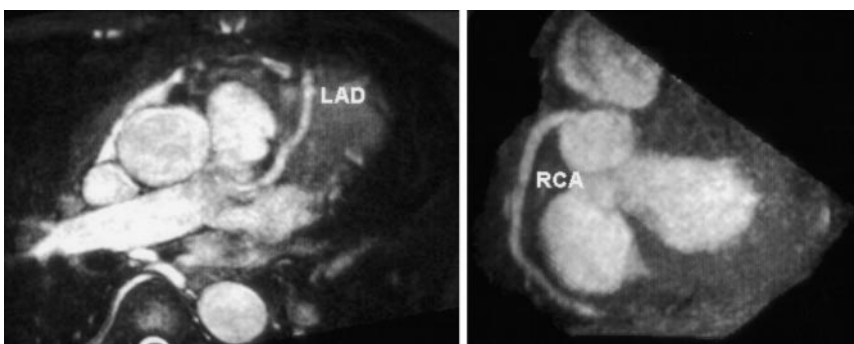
Coronary angiography by MRI showed no significant luminal narrowing.
